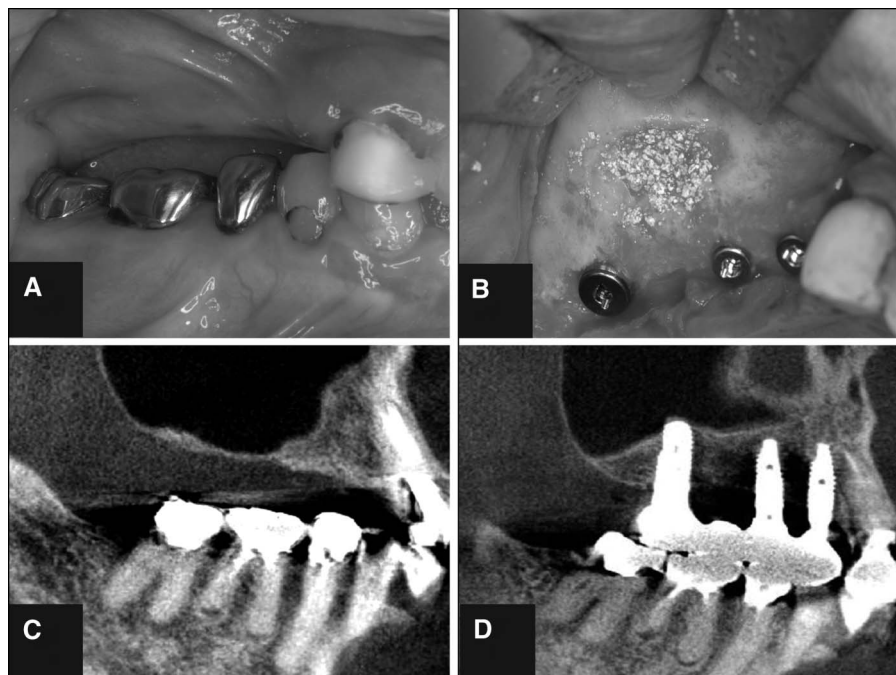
The treatment protocol of the present study for the simultaneous approach. A, The preoperative intraoral photograph shows the right premolar and molar sites. B, Simultaneous maxillary sinus floor augmentation and implant insertion. C, The preoperative cone-beam computed tomography (CBCT) radiograph. D, The 1-year postoperative CBCT radiograph.
